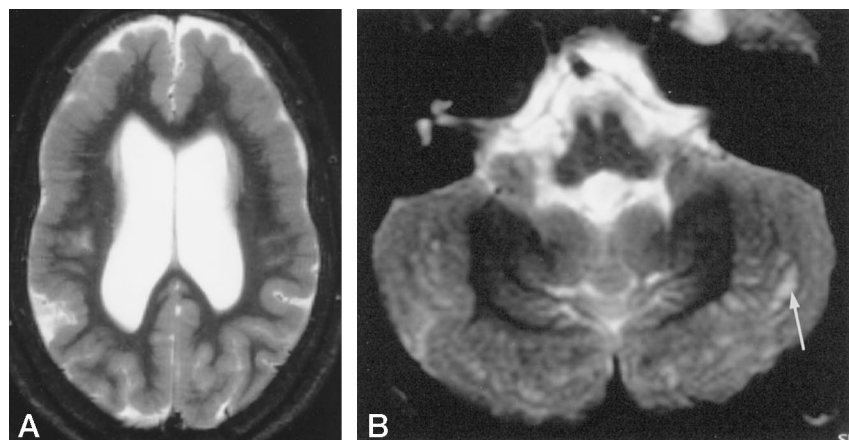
Axial T2-weighted MR images in a 15-year-old girl. The frontal and parietal lobes show thickening of the cortex with shallow sulci (A). At the level of the middle portion of the cerebellum, the folia appear diffusely disorganized with a bumpy gray-white matter interface (B). Note the presence of intracortical areas of high signal (arrow, B).
